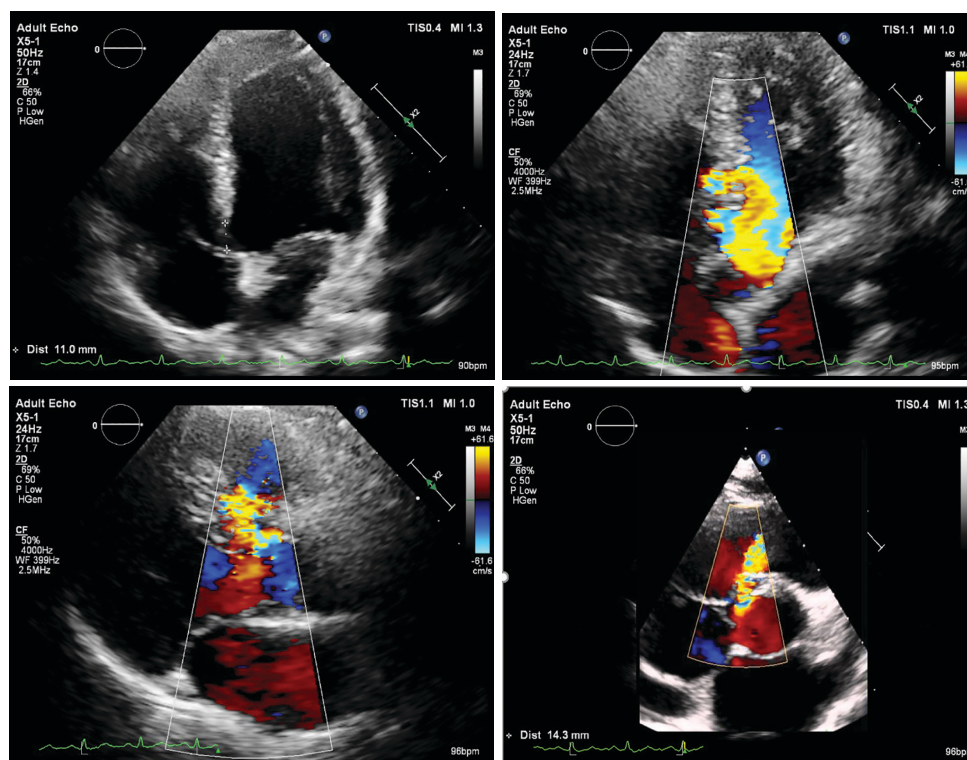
A perimembranous ventricular septal defect with small muscular VSD in 34 years old male with left - right shunt was confirmed by 2-dimensional transthoracic echocardiogram (TTE) (Panel A) and 2-dimensional TTE color Doppler (Panel B, C and D).
